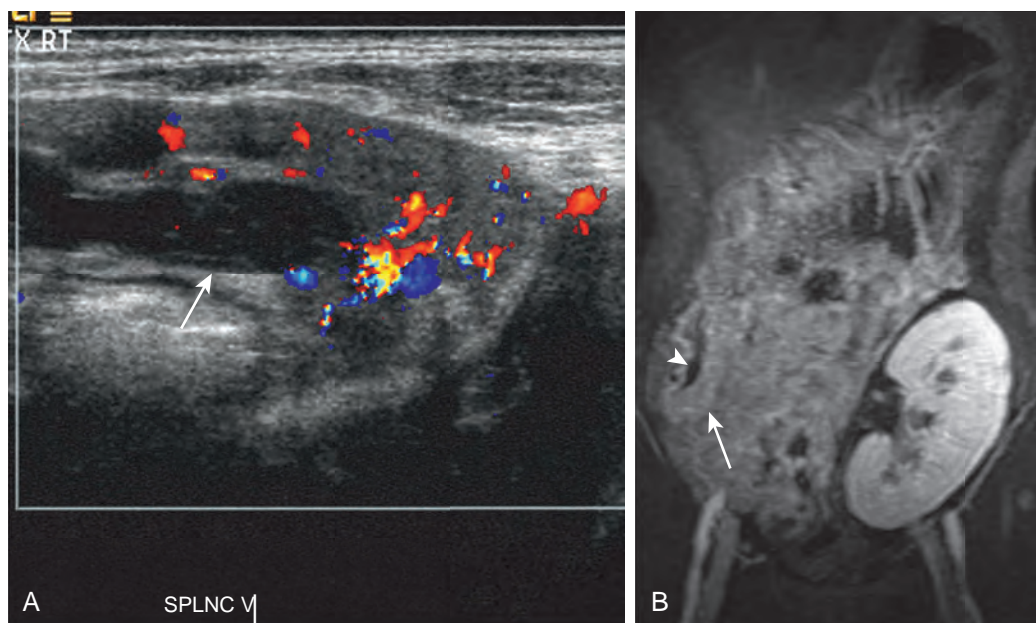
Splenic vein thrombosis in a 48-year-old man after SPK transplantation. A. Longitudinal color Doppler US of the pancreatic tail shows a distended splenic vein containing intraluminal thrombus (arrow). B. Postcontrast fat-suppressed T1-weighted coronal MR image confirms the splenic vein thrombus (arrowhead) but also demonstrates normal gland enhancement (arrow). (From Vandermeer F, Manning MA, Frazier A, et al: *Imaging of whole-organ pancreas transplants*. *RadioGraphics* 32:411–435, 2012.)
